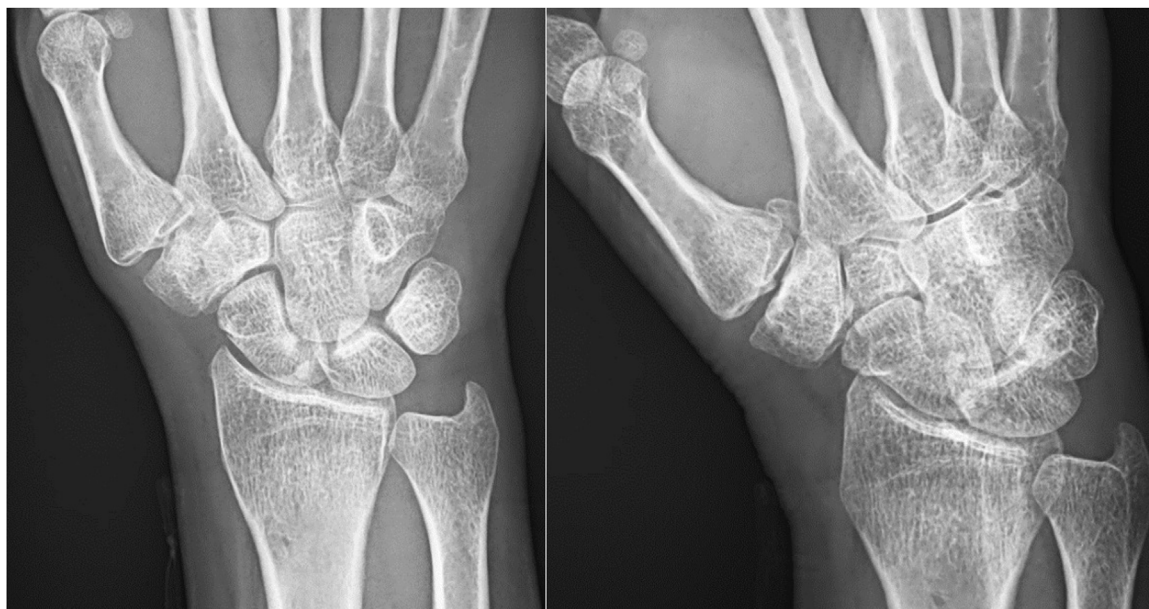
Postoperative radiographs after sixty-six months. Note the excellent congruency of the carpometacarpal joint without considerable degenerative changes.
